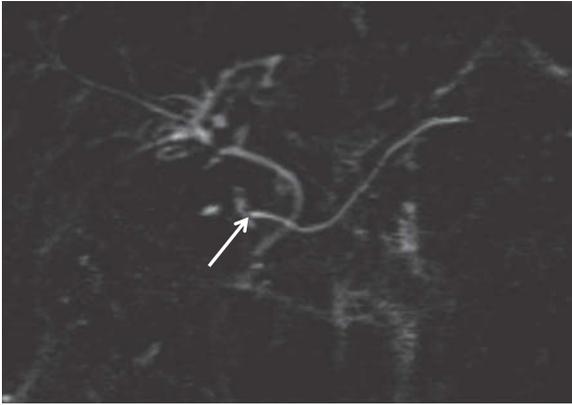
Pancreas divisum. Coronal T2-weighted image shows a non-dilated main pancreatic duct draining into the minor papilla (arrow). This is diagnostic of pancreas divisum.
